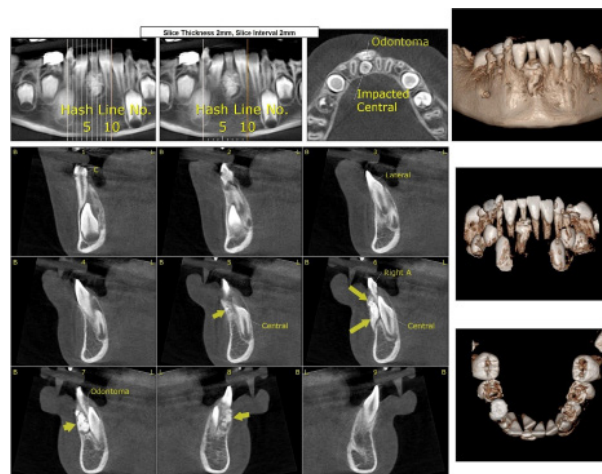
Pre-operative cone beam computed tomography views.
